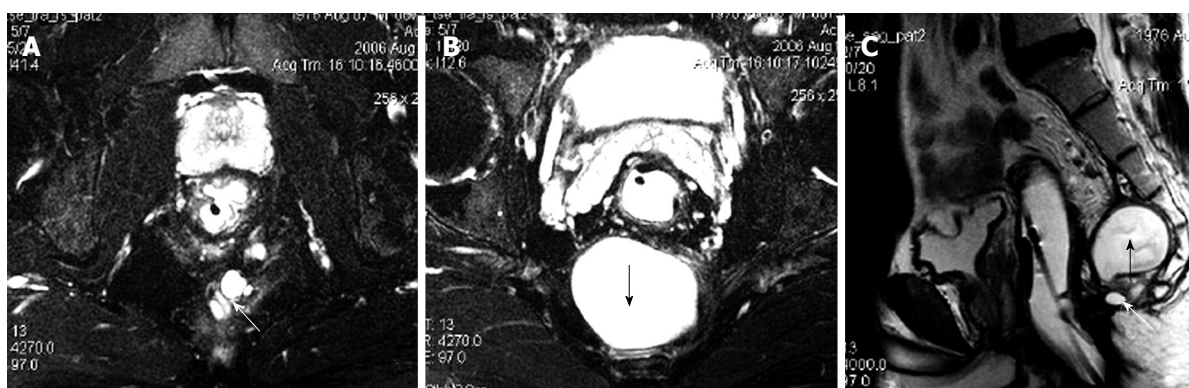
Tailgut cyst in a 30-year-old man. On T2-weighted fat-suppression (A, B) and Sagittal T2-weighted images (C), small cysts are composed to form a honeycomb (white arrows) adjacent to a main larger cyst (black arrows).
